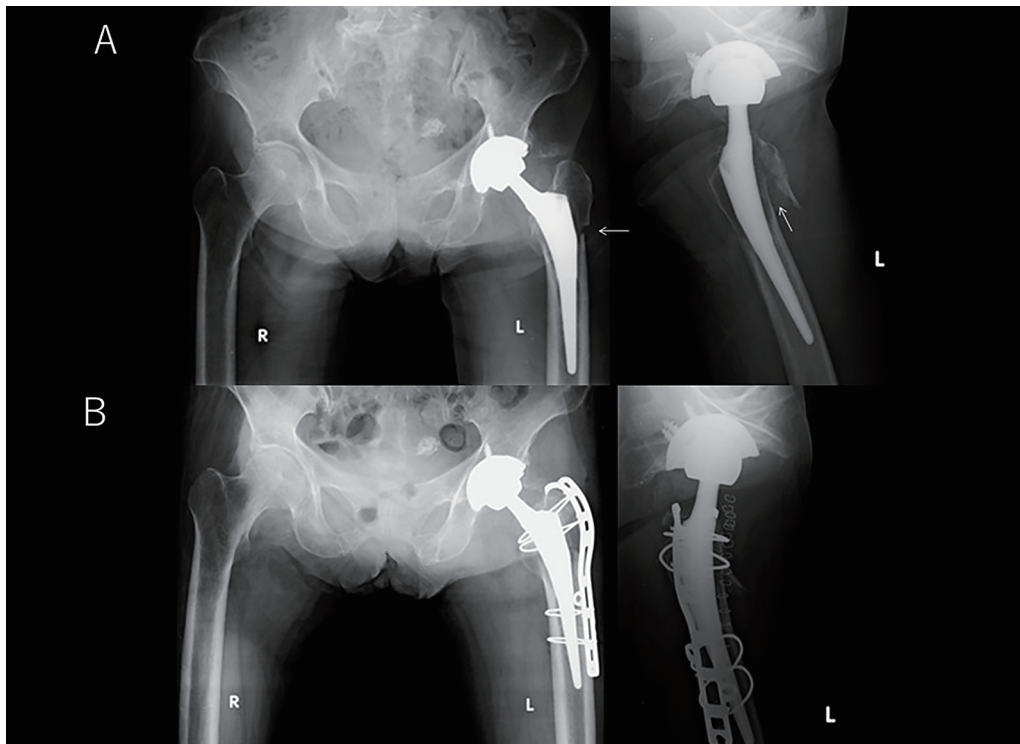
Radiographs of the patient's femur before and after surgery
